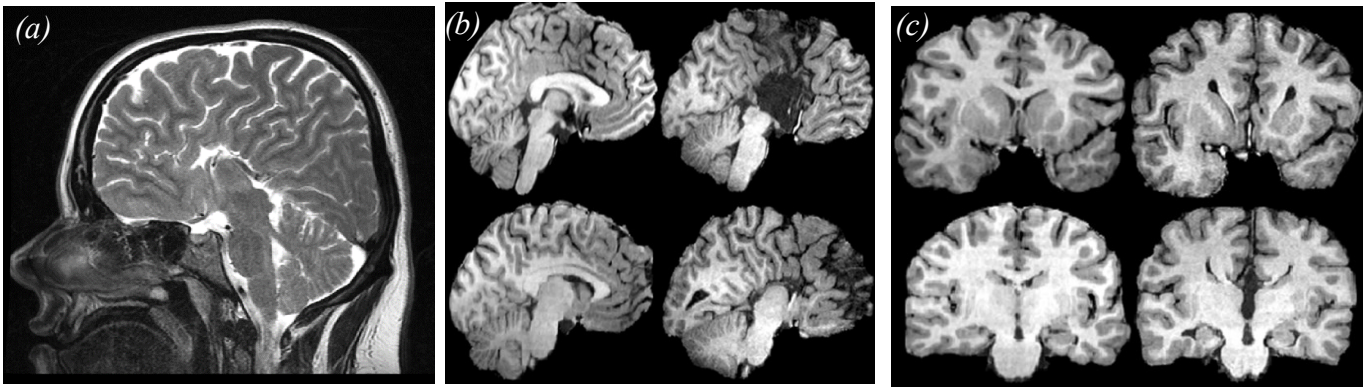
Structural MRI scans of ACC1 indicate complete agenesis of the corpus callosum in sagittal T2-weighted (panel (a)), T1-weighted sagittal (panel(b): right panel ACC1 in comparison to left panel depicting same-age neurologically-normal brain), and coronal (panel (c): right panel ACC1 in comparison to left panel depicting same-age neurologically-normal brain)
